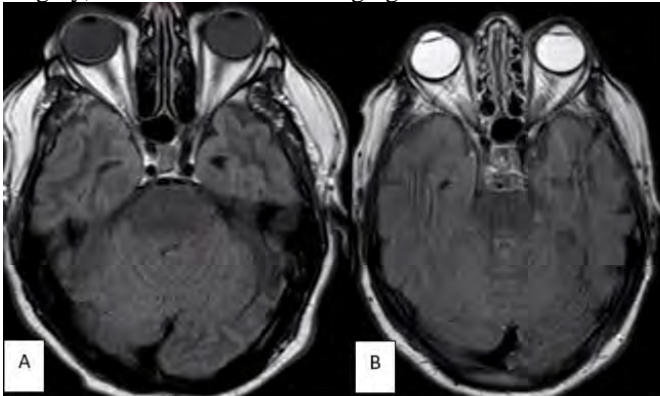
Positive (A) and strongly positive (B) GLOS on delayed axial FLAIR images acquired 36 hour and 27 hours after last GBCA administration for relapse of lymphoma (patient 1) and multiple myeloma (patient 94) respectively. No brain parenchymal or ocular abnormality was detected. The patient in B had evidence of prior bilateral cataract surgery.
